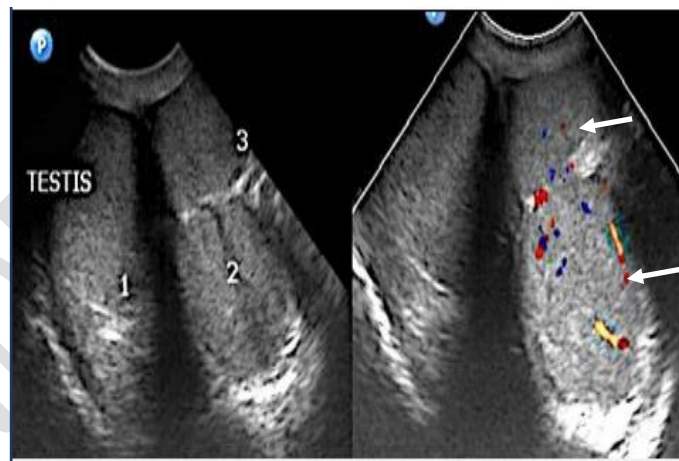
Color doppler study of scrotum showing three testicles
